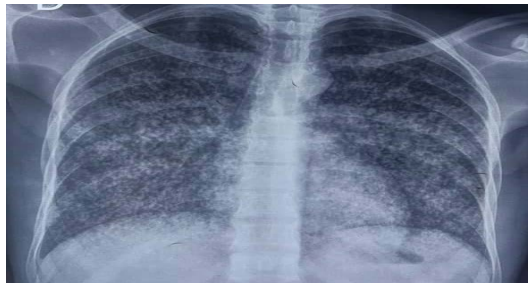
Standard frontal chest x-ray image showing numerous small dots distributed across the lung fields with an appearance similar to grains of millet.
